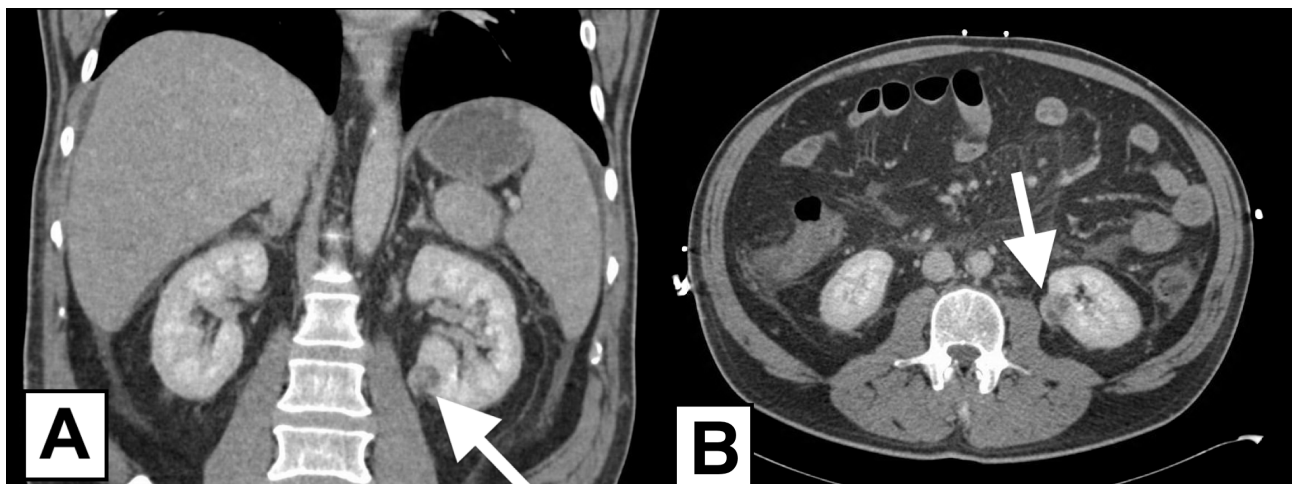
Coronal (A) and axial (B) sections of the computed tomography of the abdomen revealing an enhancing exophytic mass (white arrows) arising from the lower pole of the left kidney which was later confirmed to be clear cell renal cell carcinoma.
